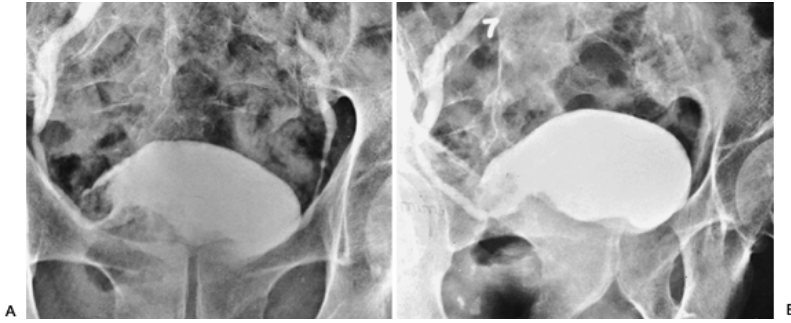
21. A: Coned-down radiographs of the bladder suggest a mass involving the inferior aspect of the right wall of the bladder. B: Radiograph taken in the left posterior oblique projection confirms irregular mass near the insertion of the right ureter consistent with carcinoma.
